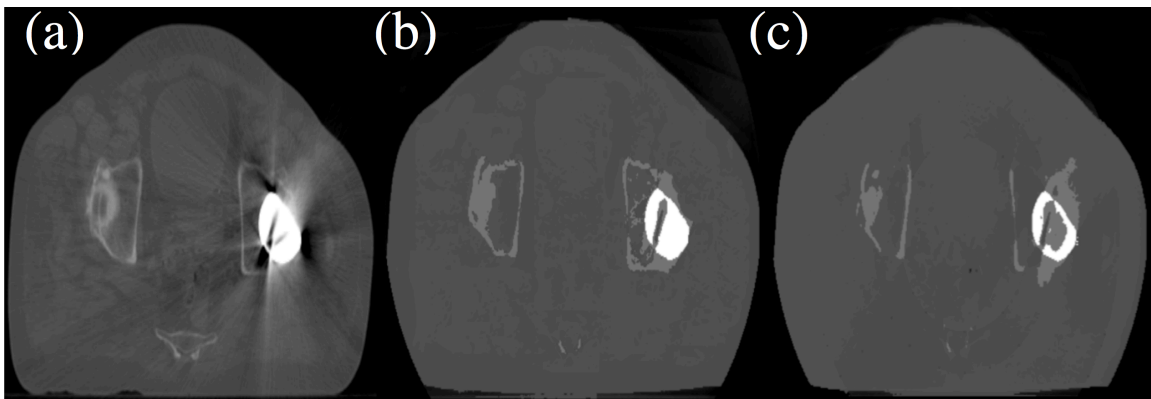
A slice of the pCT (a) and the resultant images after segmentation CBCT using the manual MLT (sCBCT_{man}) and the automated MLT (sCBCT_{auto}) (b and c respectively), showing the HU value difference in the left hip prosthesis.
